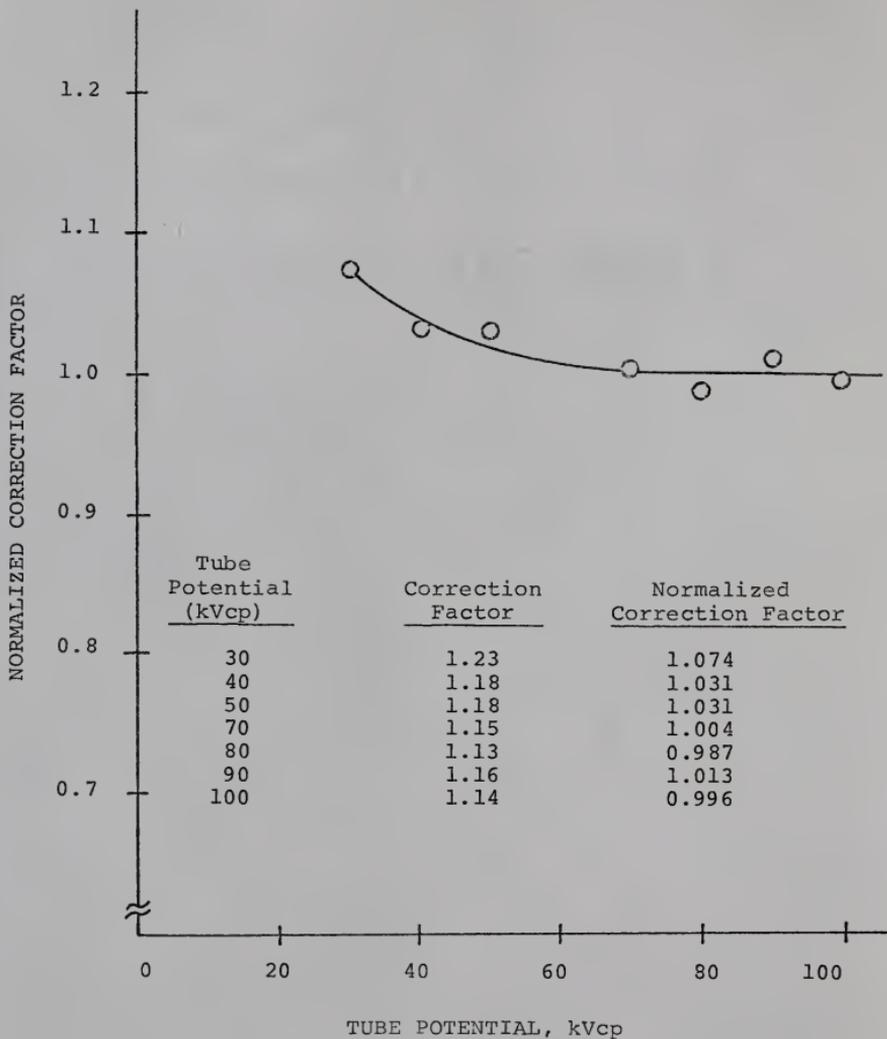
Calibration Correction Factors for Victoreen 555 as a Function of X-ray Tube Potential (HVL held constant at 1.25 mm Al Victoreen 555-10MA chamber used).
